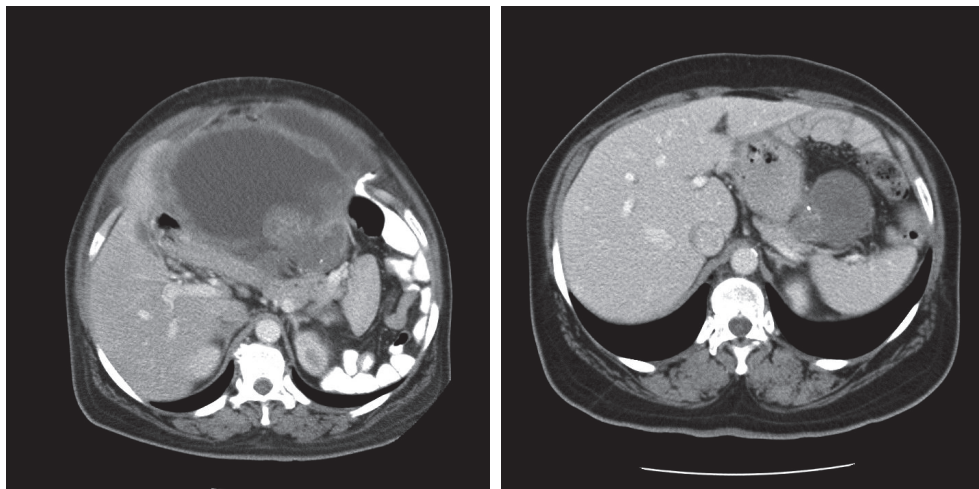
CT Scans showing Large GIST Before (left) and After (right) Neoadjuvant Imatinib.
